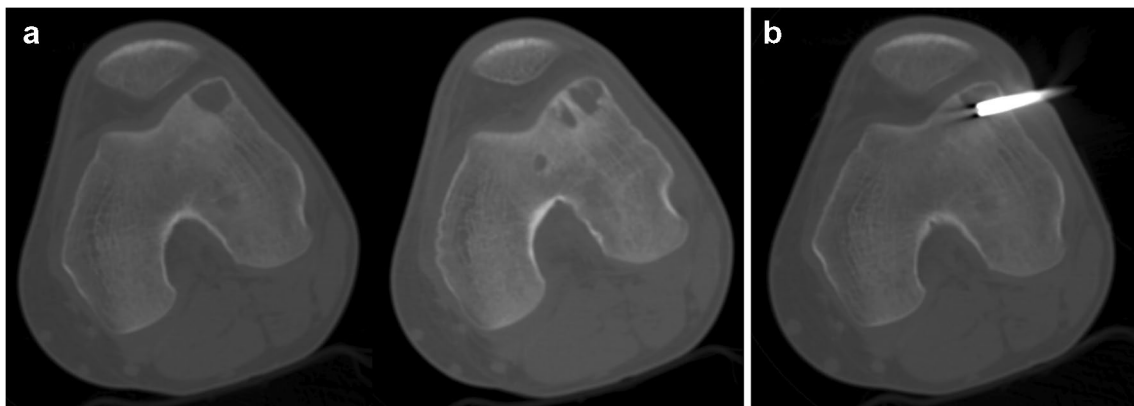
Images of a 17-year-old boy with left knee pain in the preceding 2 months and a reduced range of knee flexion/extension. a Bone window axial computed tomography scans of the knee (upper part of the epiphysis and lower part of the epiphysis) shows a multifocal
